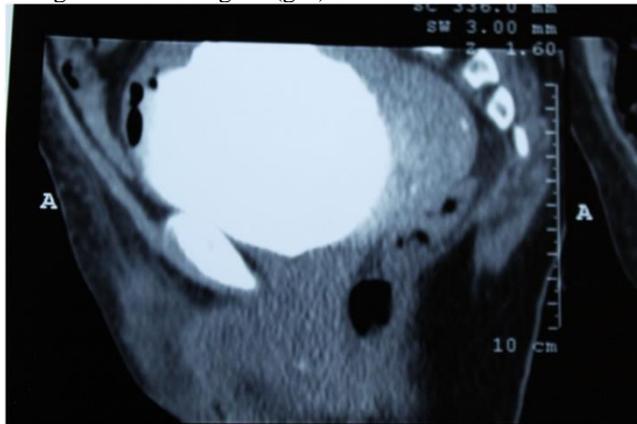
CT showing air (gas) in the left ureter
